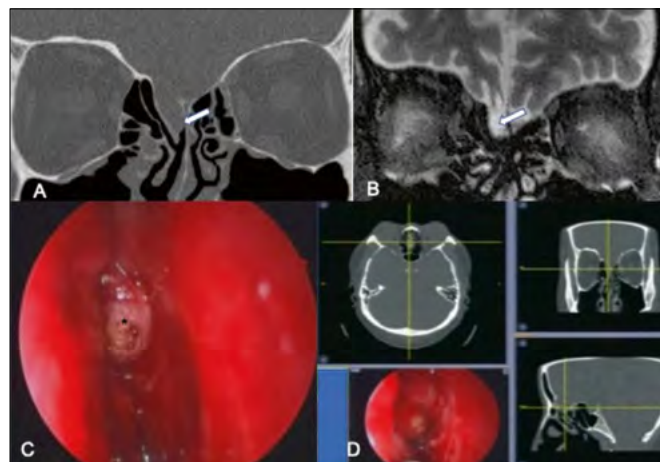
Coronal CT scan (A) and T2 weighted MRI of a case of spontaneous CSF leak due to meningocele of the right olfactory groove. The endoscopic view (C) after precise localization using Navigation System (D) yellow cross-air in the 3 planes and endoscopic view of the tip of the instrument.
